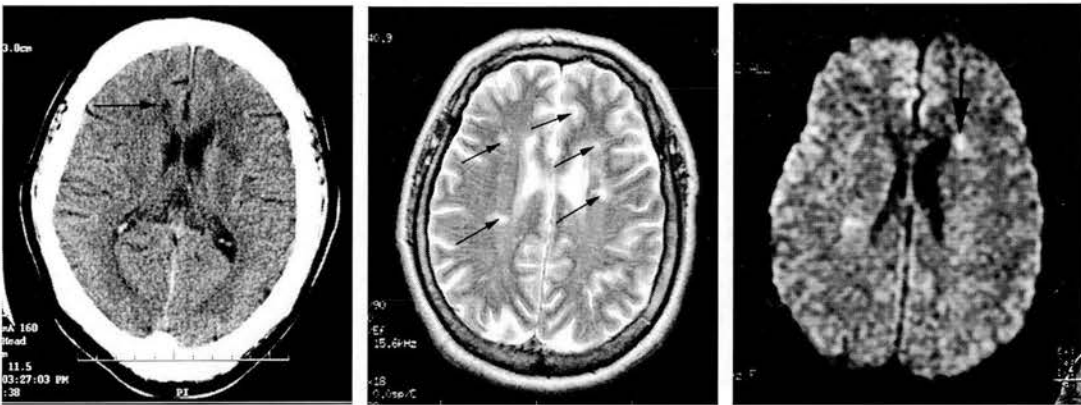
The DWI scan shows the relevant lesion*
